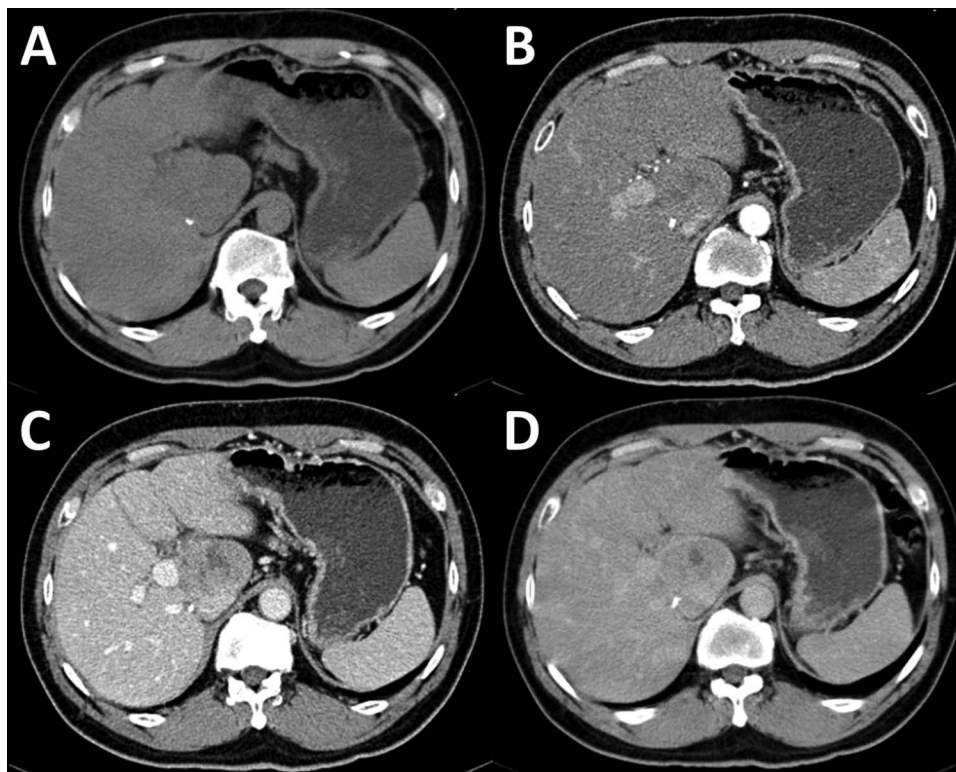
Dynamic phases CT scan of upper abdomen show 4.6×3.2 cm exophytic mass from caudate lobe with central area of necrosis (A). This lesion had slightly arterial enhancing (B) and washout on portovenous phase (C). During delay phase (5 min), peripheral enhancement was observed (D).
